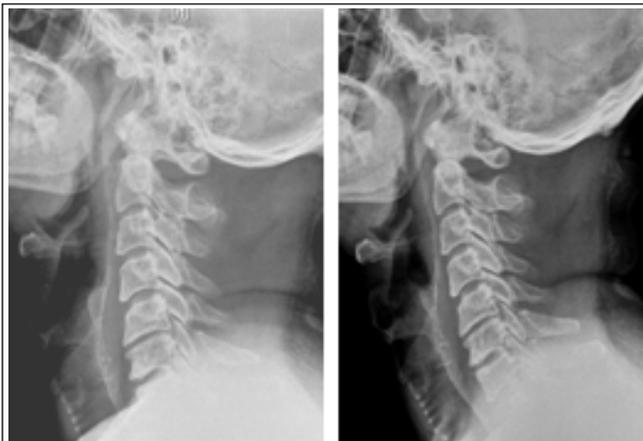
(a) Cervical spine plain X-ray lateral view shows decrease in soft tissue shadow taken at the end of the 2nd week, (b) plain X-ray taken at the end of 1 month.
